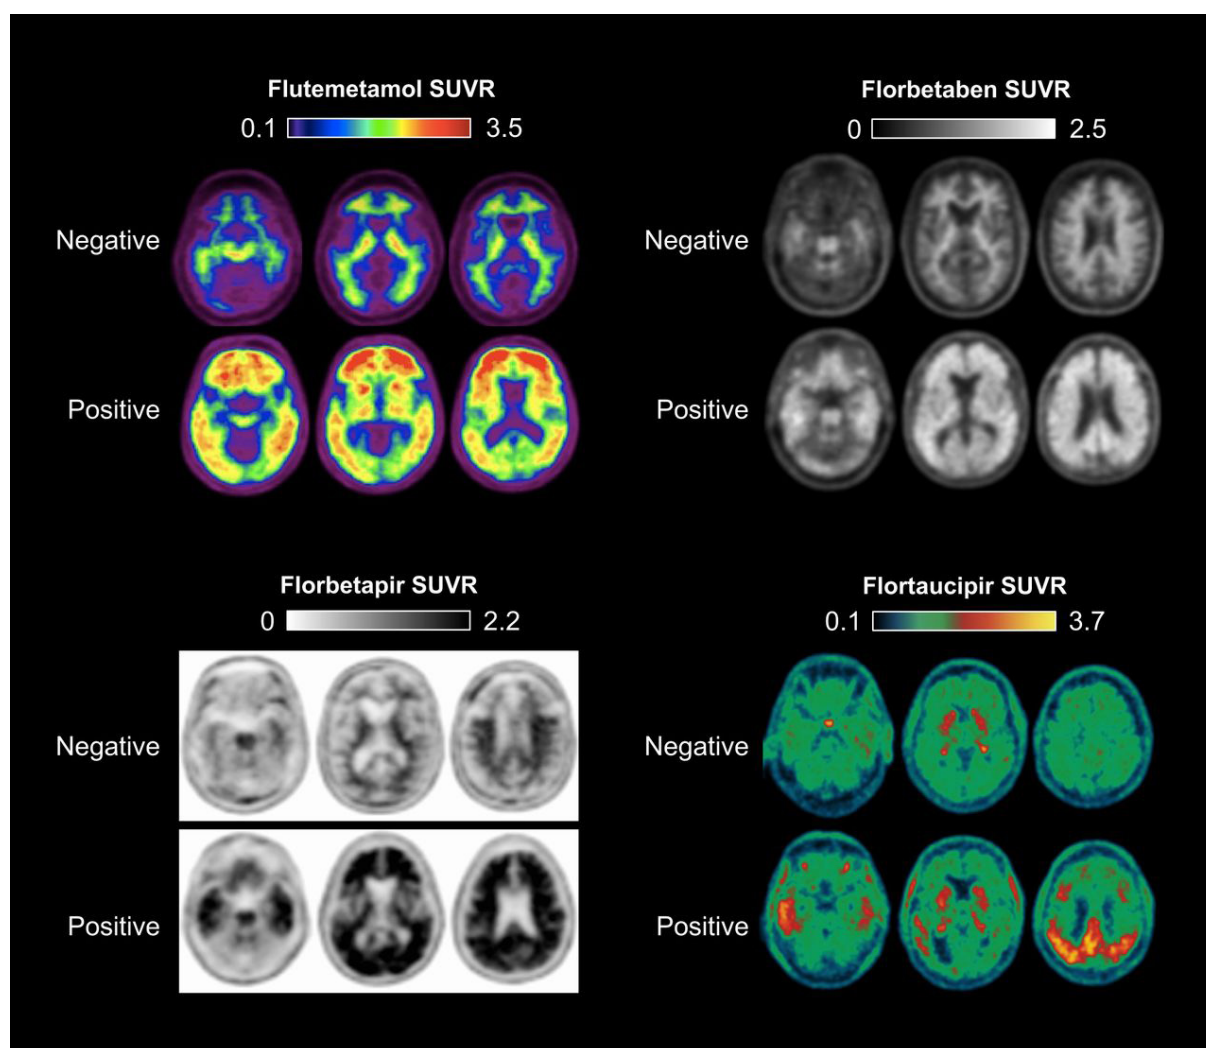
Examples of positive and negative A β and tau PET scans with FDA-approved radiotracers. SUVR images were created using pons (18F-flutemetamol), whole cerebellum (18F-florbetaben, 18F-florbetapir), and inferior cerebellar gray matter (18F-flortaucipir) as reference regions. Each image is displayed in approved gray and white or color scale for clinical interpretation¹⁴
